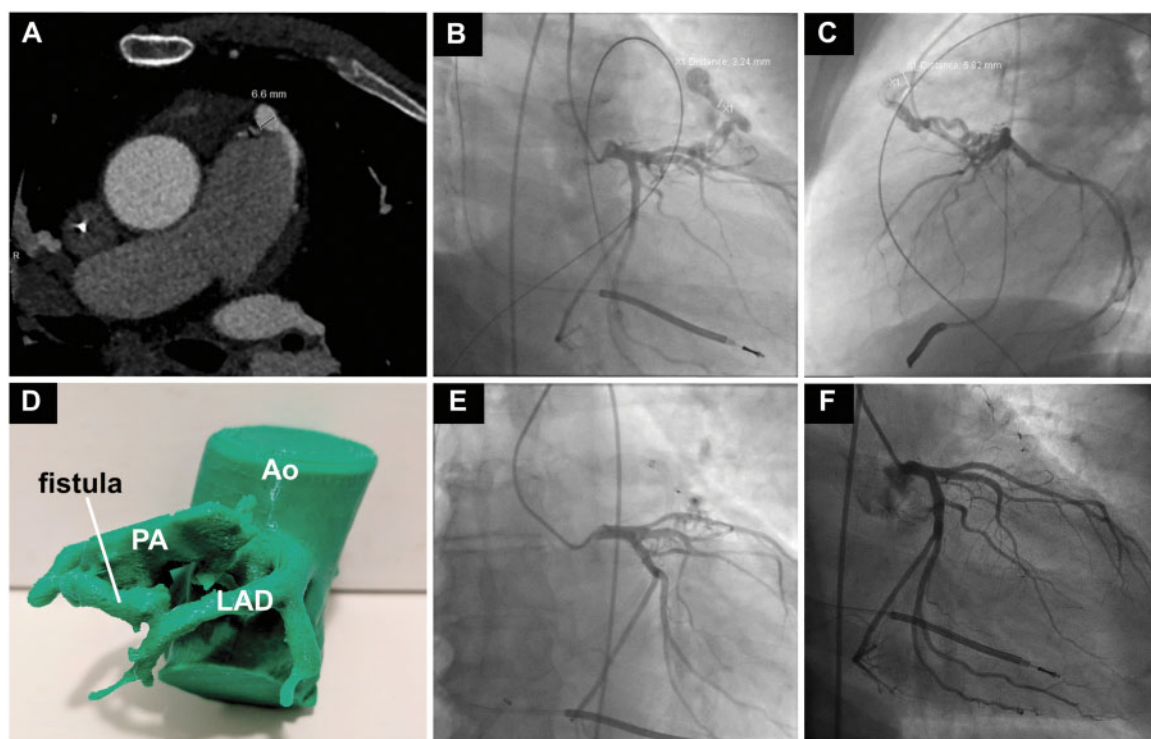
(A) Cardiac computed tomography demonstrating the left anterior descending artery to pulmonary artery fistula size and location. (B and C) Pre-procedural planning angiogram highlighting the complex course of the fistula. (D) Annotated three-dimensional printed model of the aortic root, left anterior descending artery, pulmonary artery, and fistula. (E) Procedural angiogram with retrograde delivery of two vascular plugs. (F) Angiogram at 1-year follow-up confirming successful closure of the fistula.
